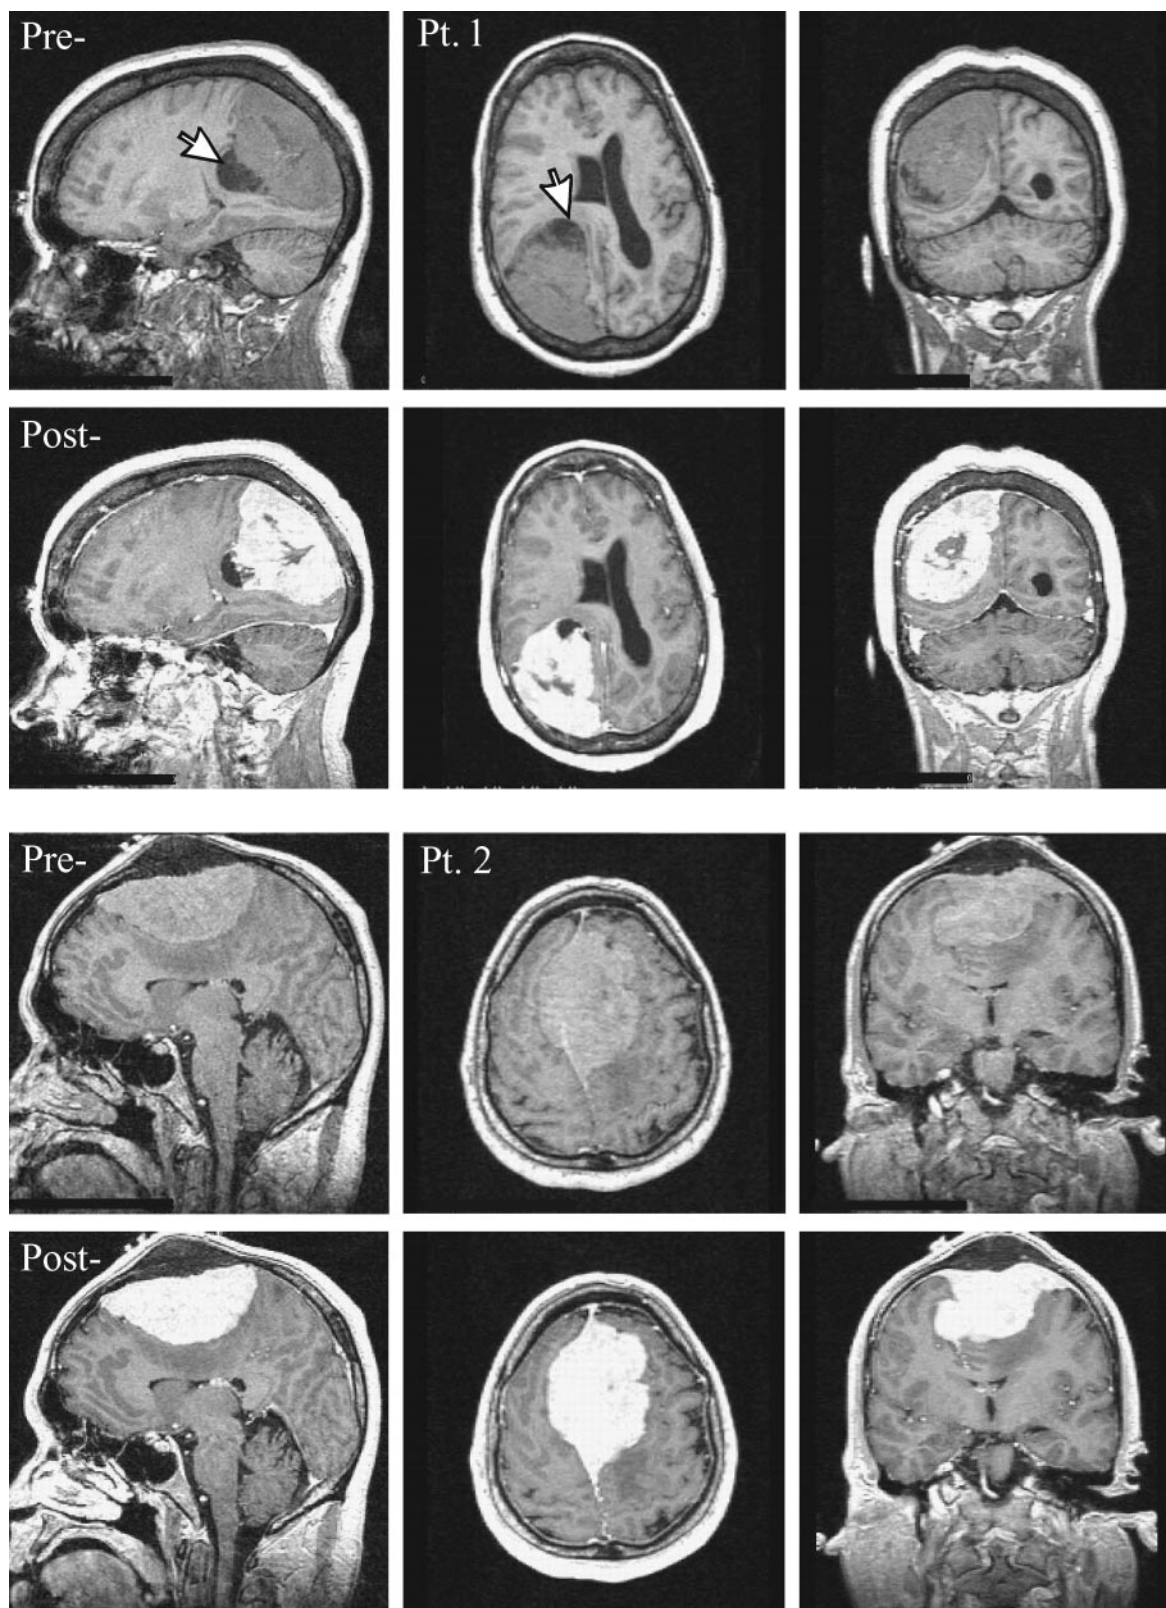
Top*, Sagittal, axial and coronal T1-weighted images pre- and postcontrast for patient 1. Note the large ($6 \times 5 \times 5 \text{ cm}^3$) extra-axial lesion in the right parietal region, surrounding small cysts (largest $\sim 1.5\text{-cm}$ diameter, *arrow*) and marked mass effect on the right lateral ventricle, midline shift, and sulcal effacement.
